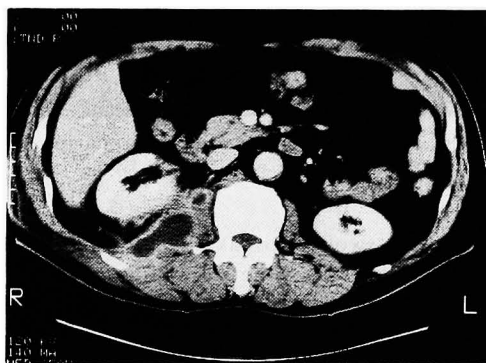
CT scan of Case 2 demonstrates clearly encapsulated low density areas not enhanced by contrast media.
